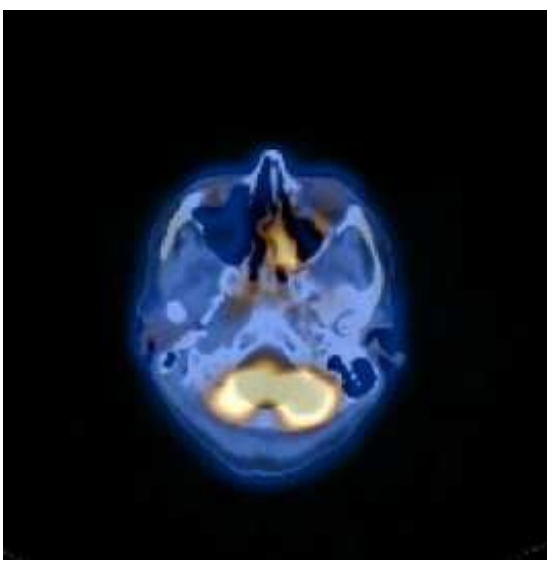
PET/CT revealing FDG avidity corresponding with MRI and CT findings
